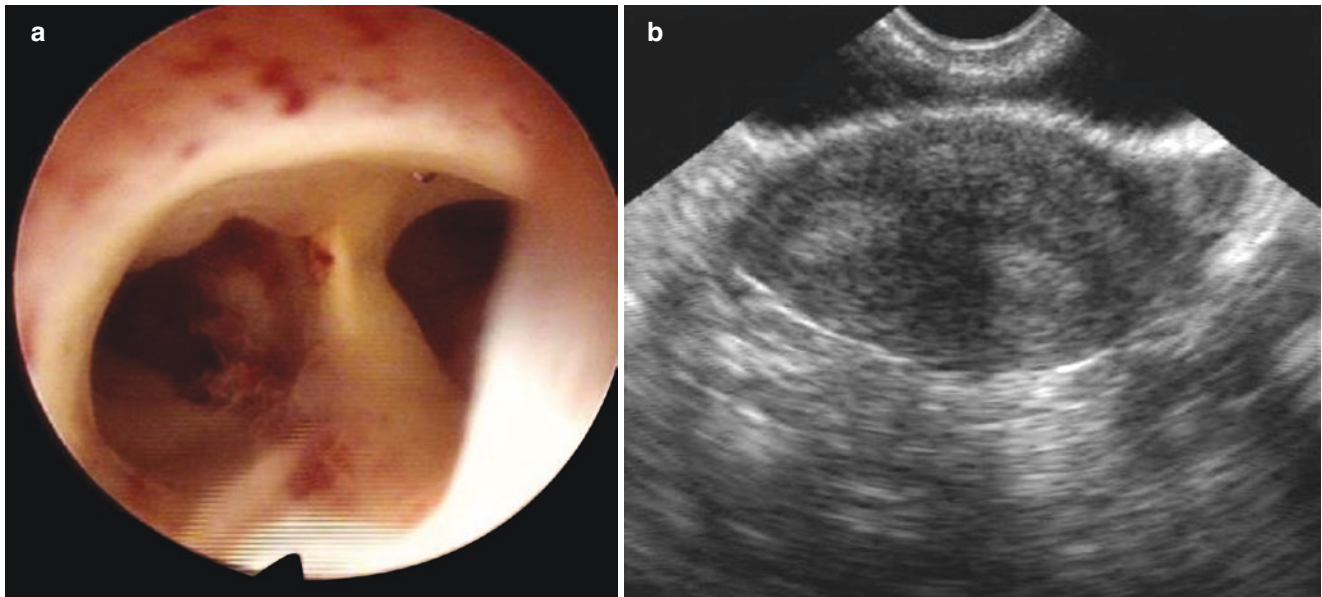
uterus septum. (a) The incomplete uterus septum is displayed under the hysteroscopy examination. Two uterine cavities are shown in the fundus uteri. (b) Ultrasound examination shows the endometrium in the shape of the Chinese character “八” in uterus septum cases
